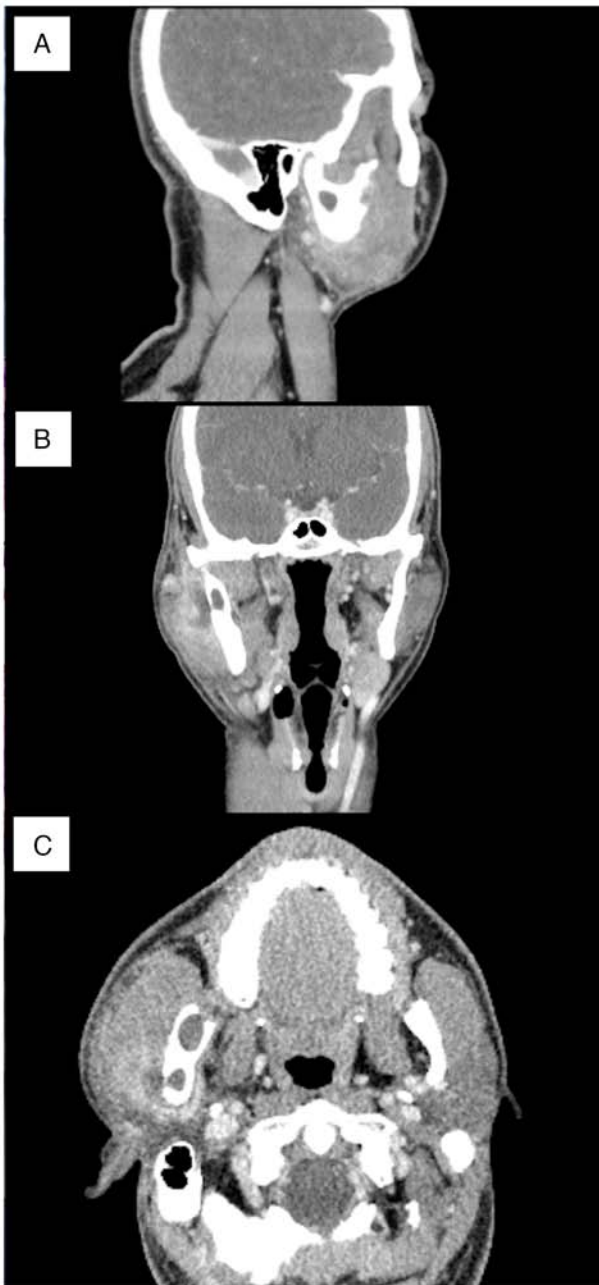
Contrast computed tomography images. (A) Sagittal, (B) coronal and (C) horizontal views of abscess formation at the cyst at the base of the condyle and swelling of the surrounding tissues, including the parotid gland.
